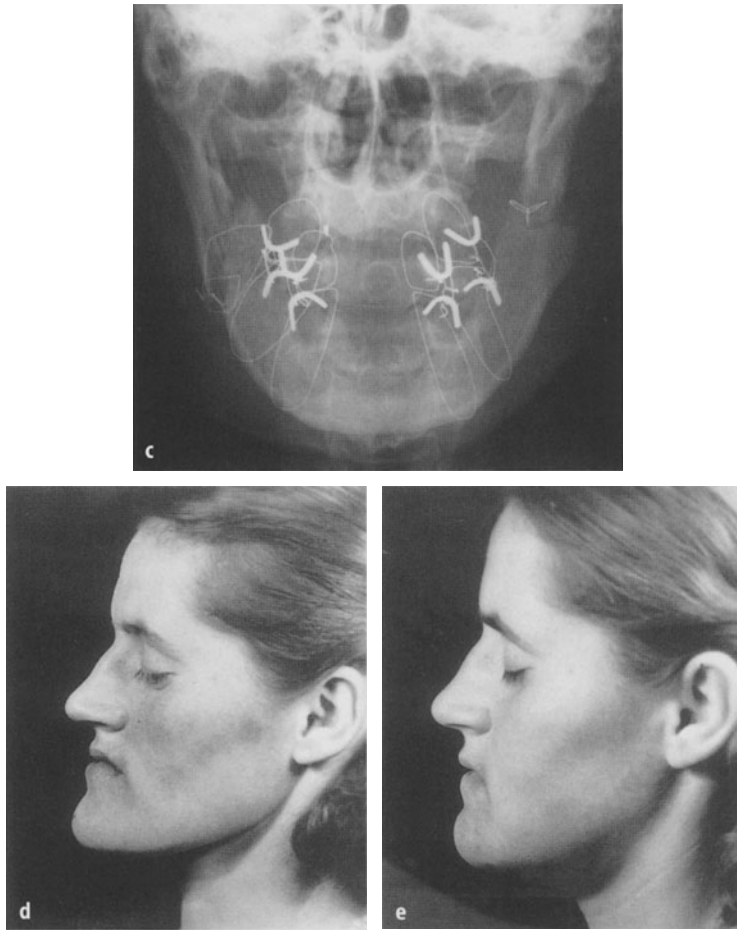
First attempt at sagittal splitting of the ascending ramus (17 February 1953). c P.a. radiograph of the mandible with intermaxillary fixation after vertical osteotomy on the right side by R. Trauner and sagittal splitting of the ramus on the left side by H. Obwegeser, on an edentulous patient. d, e Patient's profile before and 3 months after surgery
